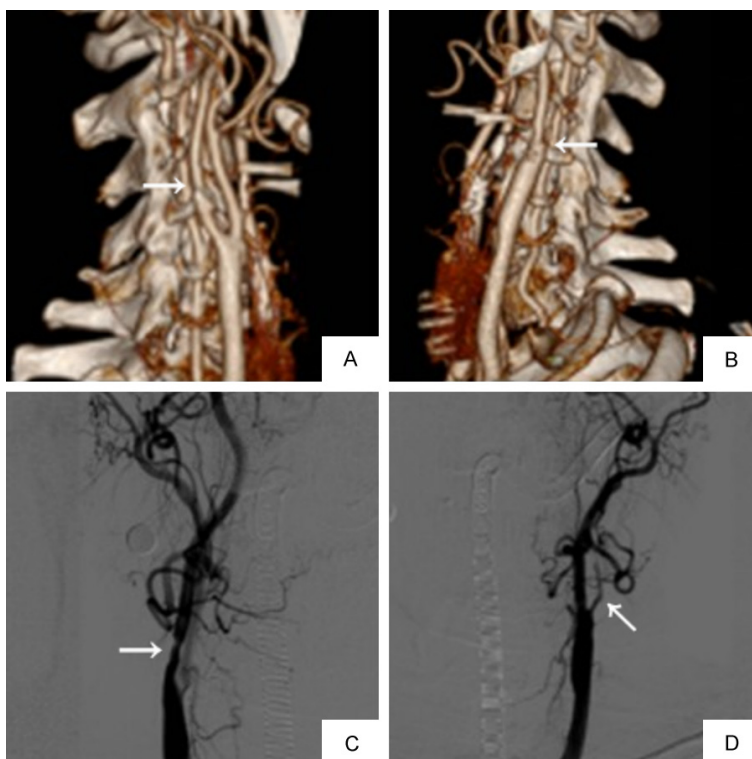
A. Carotid CTA showed severe atherosclerotic stenosis of the right internal carotid artery; B. Carotid CTA showed complete occlusion of the left internal carotid artery; C. DSA further confirmed severe atherosclerotic stenosis of the right internal carotid artery; D. DSA further confirmed complete occlusion of the left internal carotid artery.
